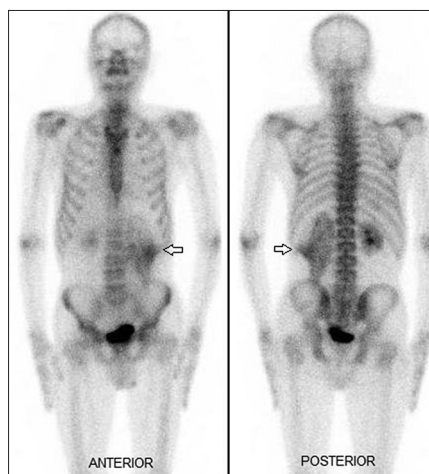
Whole body ^{99m}Tc -methylene diphosphonate bone scintigraphy shows diffuse abnormal tracer activity (arrow) in the left perirenal region. There is no evidence of any osteoblastic skeletal lesions
